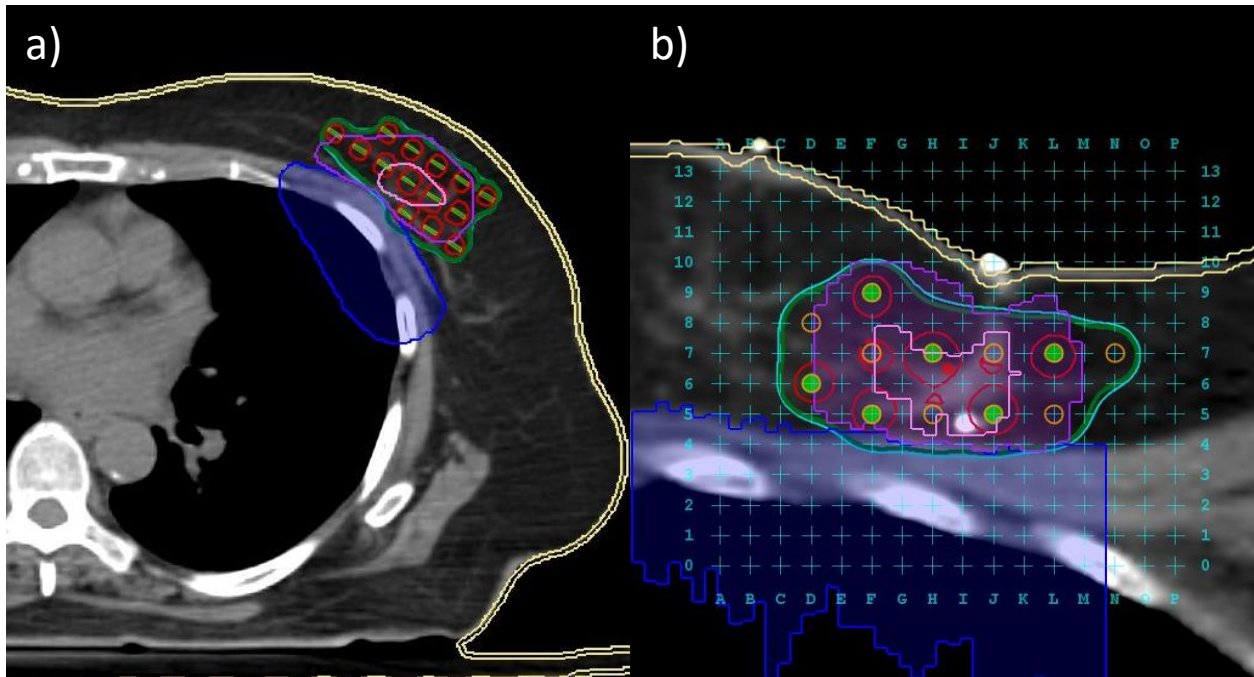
CT images showing a typical PBSI brachytherapy plan on a) an axial slice and b) an image re-sliced perpendicular to the fiducial needle (red dot in the centre of the overlaid template). The CTV, outlined in pink, is expanded to a PTV outlined in purple. A 2 mm thick skin rind is outlined in yellow and the chest wall is represented as a shaded blue region. Needle locations are shown as orange circles with seeds shown in light green as dashes in a) and solid circles in b). Isodose lines for 90 % (light blue), 100 % (dark green), and 200 % (red) of the prescription dose (90 Gy) are included. Image credit: Dr. Elizabeth Watt. For permission to reproduce figure see Appendix A.3
